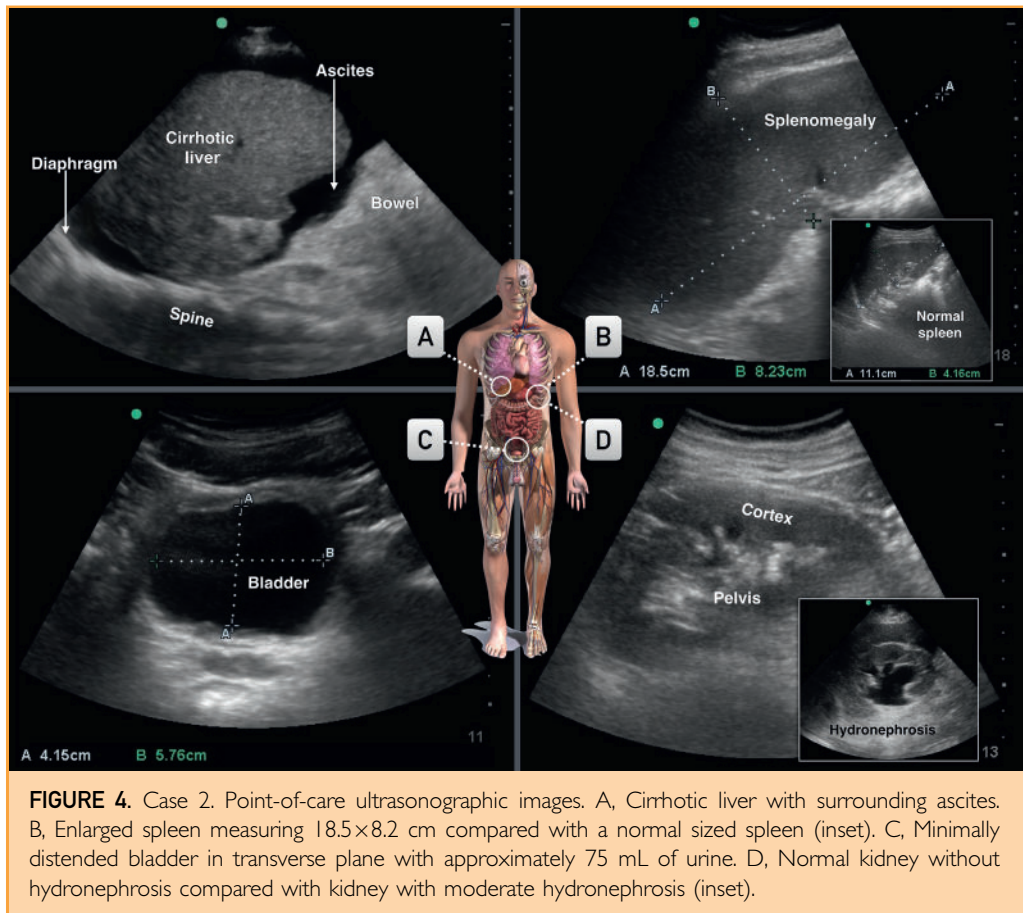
Case 2. Point-of-care ultrasonographic images. A, Cirrhotic liver with surrounding ascites. B, Enlarged spleen measuring 18.5×8.2 cm compared with a normal sized spleen (inset). C, Minimally distended bladder in transverse plane with approximately 75 mL of urine. D, Normal kidney without hydronephrosis compared with kidney with moderate hydronephrosis (inset).
